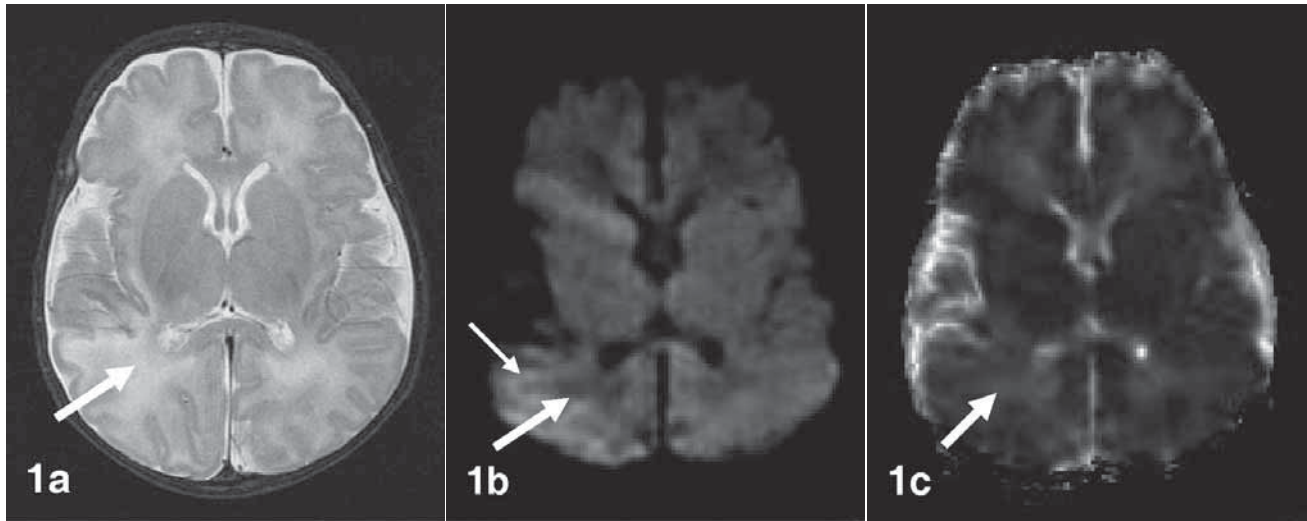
1a-c Brain MRI images performed 7 days subsequent to birth. (a). From the T2-weighted image, the infarcted area (white arrow) appears hyperintense. (b). This diffusion-weighted image (DWI) shows mild hypointensity in the infarcted area (large white arrow) of the brain, indicating infarcted immature brain in the subacute stage. The hyperintensity of the DWI in the peripheral infarcted area (small white arrow) was due to T2 shine-through effect. (c). In this ADC map, the mild hyperintensity apparent in the infarcted area (white arrow) confirmed ischemic stroke in the subacute phase.
